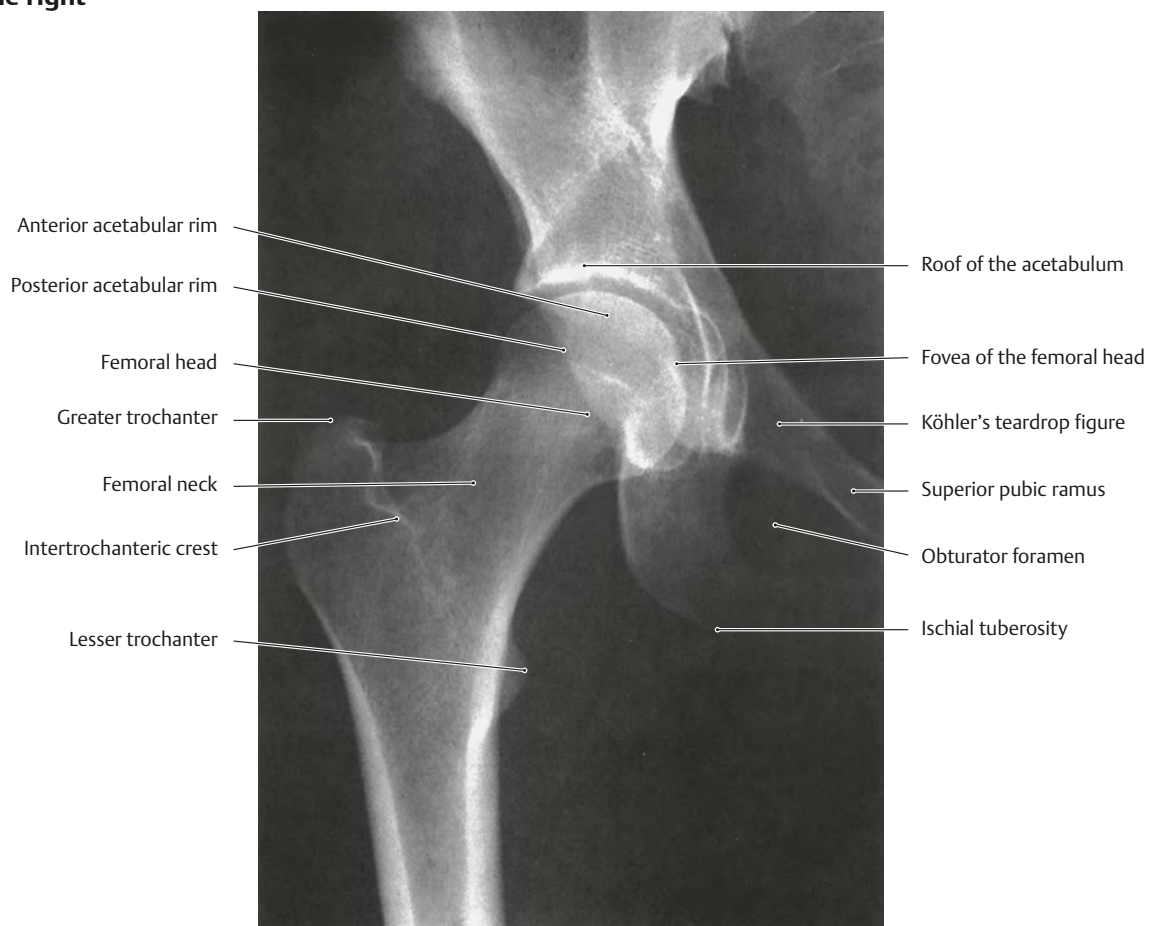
Radiograph of right hip joint with limb abducted laterally (Lauenstein view)
